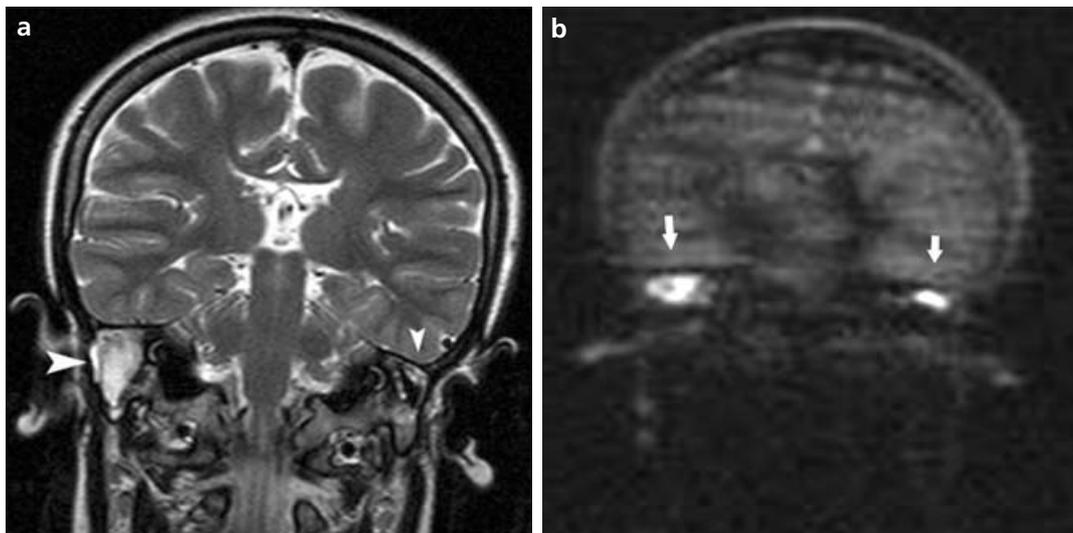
a, b. A coronal TSE T2-weighted MRI showing extensive bilateral attic/antral hyperintense lesions on the right side (*arrowheads*) under the tegmen, suggestive of recurrent cholesteatoma (a). A coronal HASTE DWI (b=1000) of the same patient with bilateral nodular markedly hyperintense lesions (*arrows*) consistent with recurrent cholesteatoma (b).
